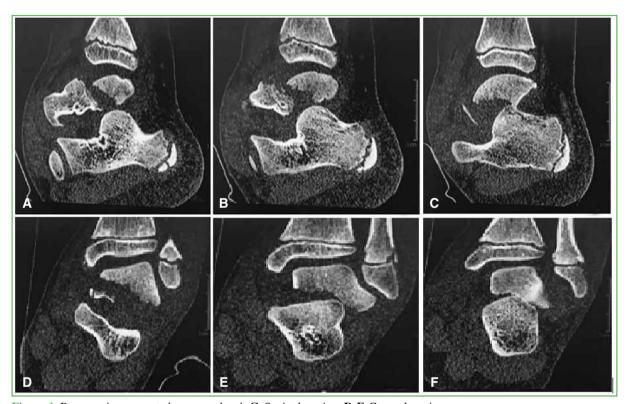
Preoperative computed tomography. A-C. Sagittal section. D-F. Coronal section.
